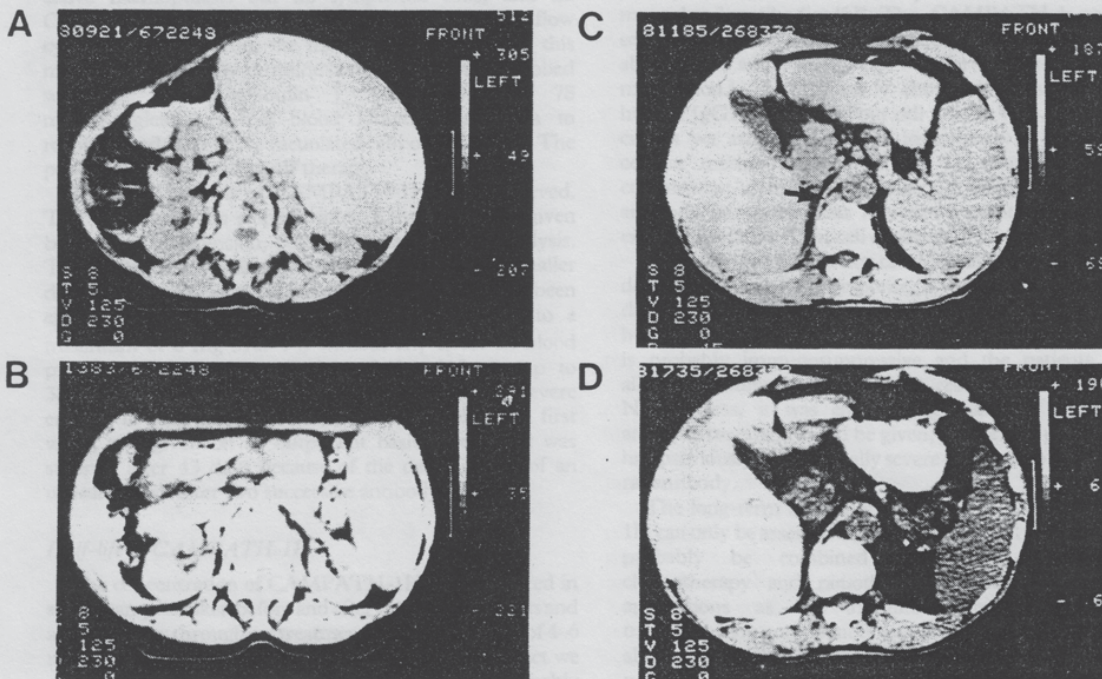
Computed tomography scans showing affected spleens and lymphnode.
